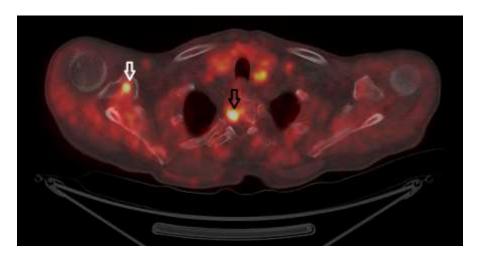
The white arrow indicates increased FCH uptake in the right scapula (SUVmax 5.6), while the black arrow shows increased uptake in the Th2 vertebral body (SUVmax 17.6) — both highly suspicious for metastases from pulmonary carcinoid.
